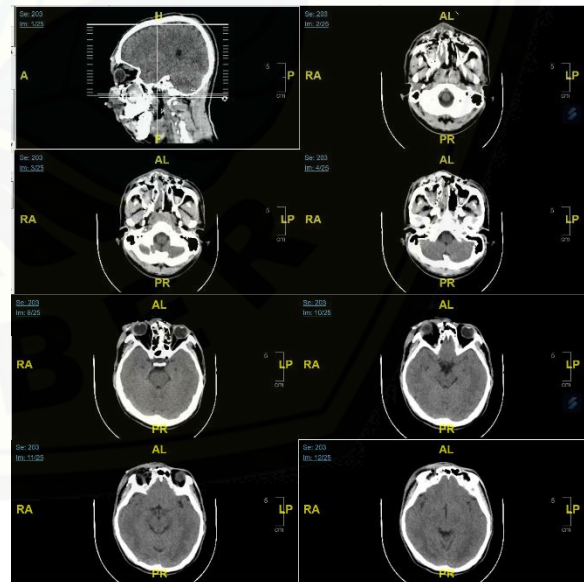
CT scan imaging before surgical intervention
